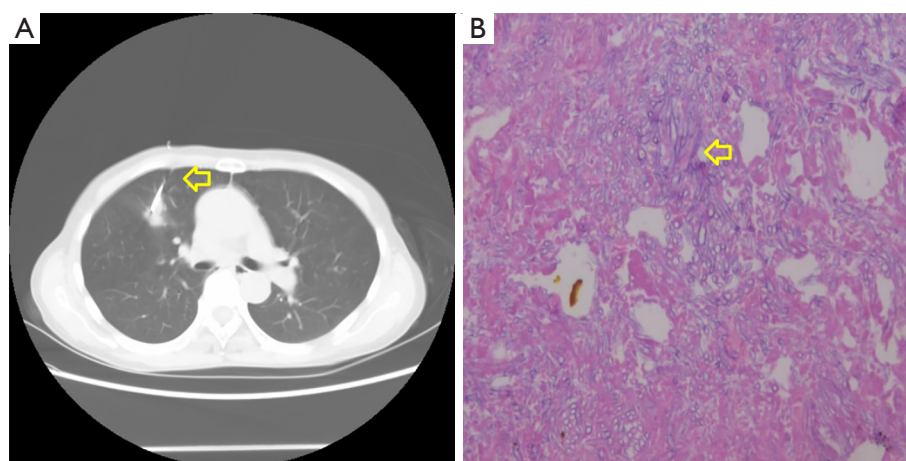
Lung biopsy. (A) Fine-needle aspiration was done in right middle lobe guided by CT findings to make a definitive diagnosis of IPA (yellow arrow); (B) typical *Aspergillus* hyphae can be observed in lung tissues (HE, 200×) (yellow arrow).
